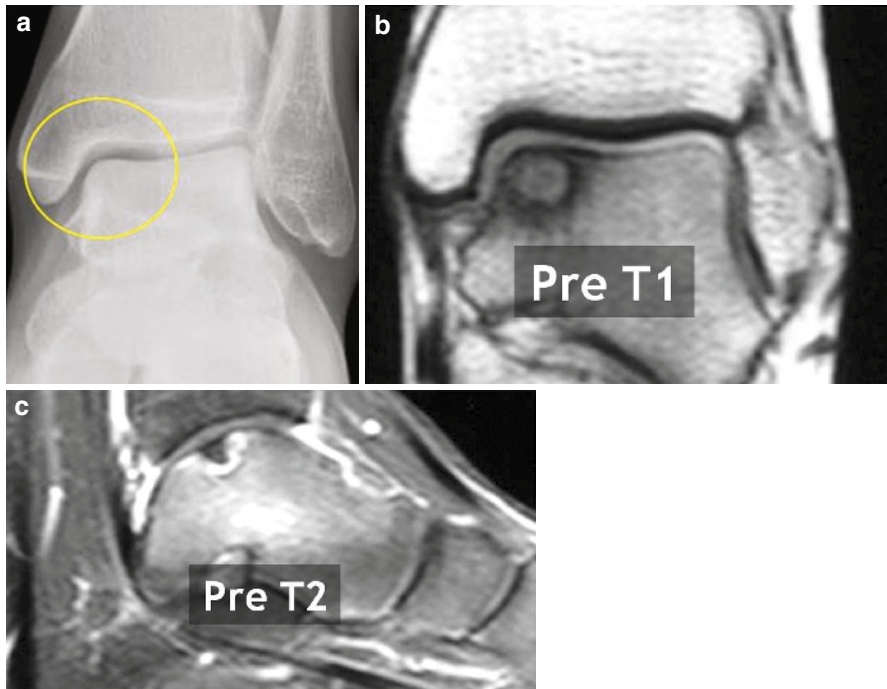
Radiograph and MRI images of an osteochondrosis dissecans (OCD) tali at the medial talar shoulder (Berndt and Harty Stage II, Hepple and Winson stage IIa; (a), anteroposterior radiograph; (b), coronal T1 reconstruction; (c), parasagittal T2 reconstruction)^{7,21}
